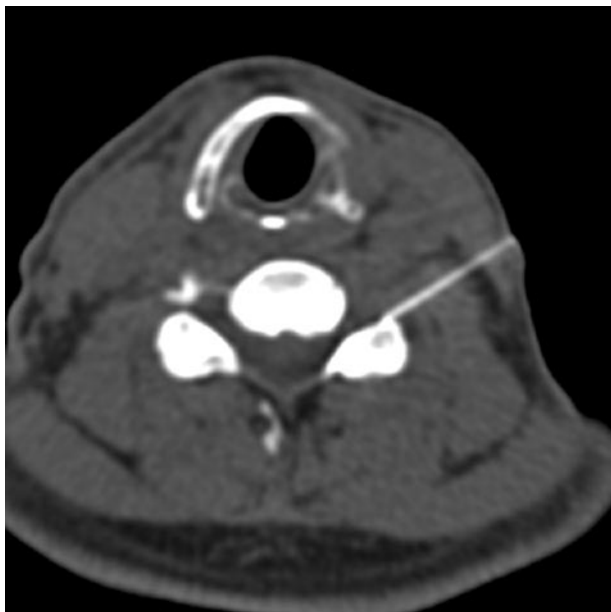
Axial CT fluoroscopic image demonstrates the approach used to access the neural foramen. Needle tip is located along the posterior foramen, well away from the vertebral vessels but directly adjacent to the exiting nerve root.
